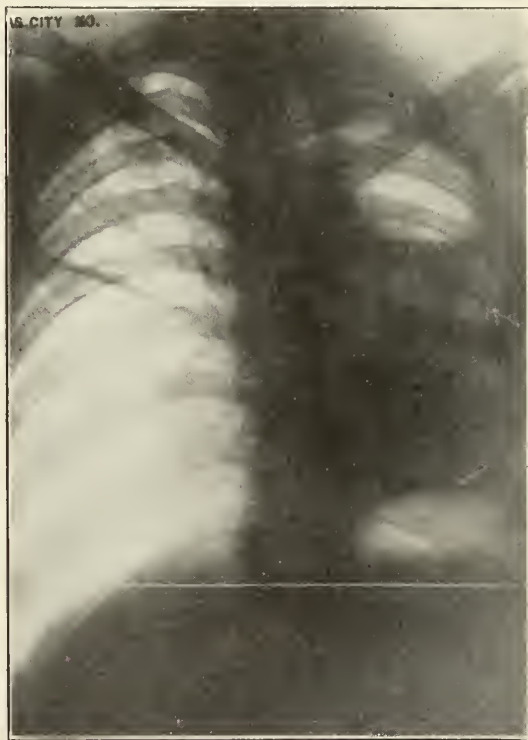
Roentgenogram (August 16, 1929) of chest shortly after left-sided phrenicectomy. Note elevation of diaphragm on left, infiltration in lower chest, large cavity size of a tennis ball or larger in left upper lobe and smaller cavity with arrow pointing toward it. Smaller cavity closed after hemidiaphragmatic paralysis but larger cavity not much affected.
